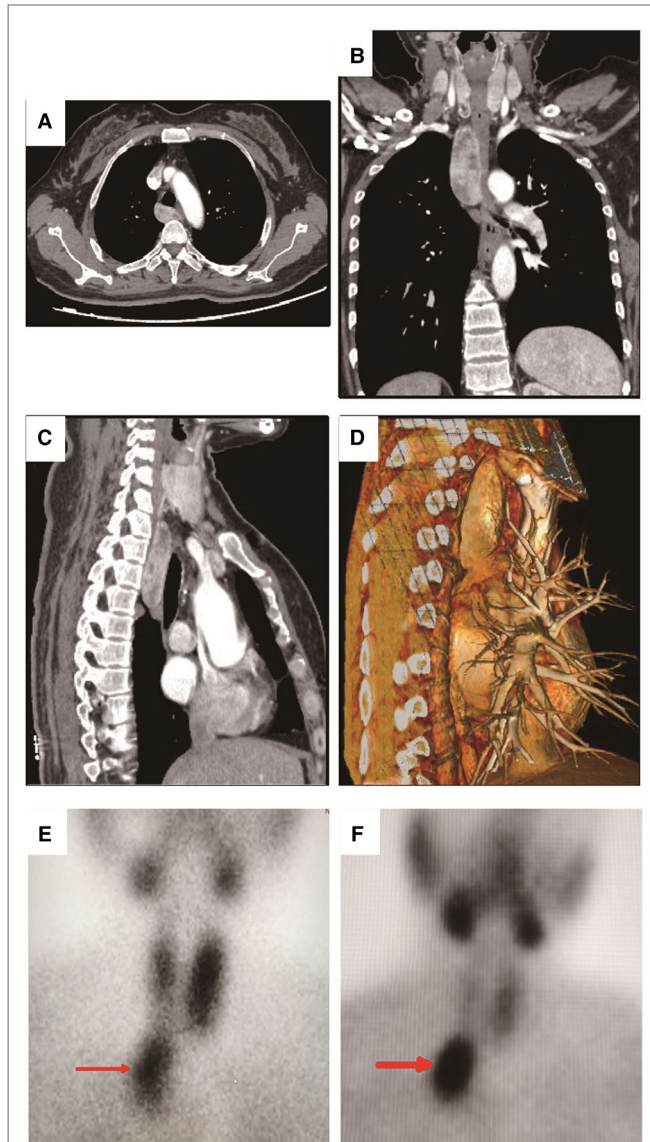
Computed tomography (CT) scan and ^{99m}Tc -Technetium sestamibi scanning of the patient. (A) Transverse view of the CT scanning showed a mixed density mass with uneven enhancement in the posterior mediastinum. The maximum cross-section size was about 3.3×1.9 cm.; (B) Coronal view of the CT scanning; (C) Sagittal view of the CT scanning; (D) Three-dimensional reconstruction in sagittal view of the CT scanning; (E) The 15th minute static imaging: the left thyroid lobe was more prominent, whereas the uptake of imaging agent in the right thyroid lobe was decreased; In addition, localized abnormal uptake of imaging agent under the right thyroid lobe was found (as shown by the red arrow). (F) The two-hour delayed imaging: the uptake of thyroid imaging was lower than that before, the abnormal imaging agent concentration under the right thyroid lobe was clearly displayed (as shown by the red arrow).
